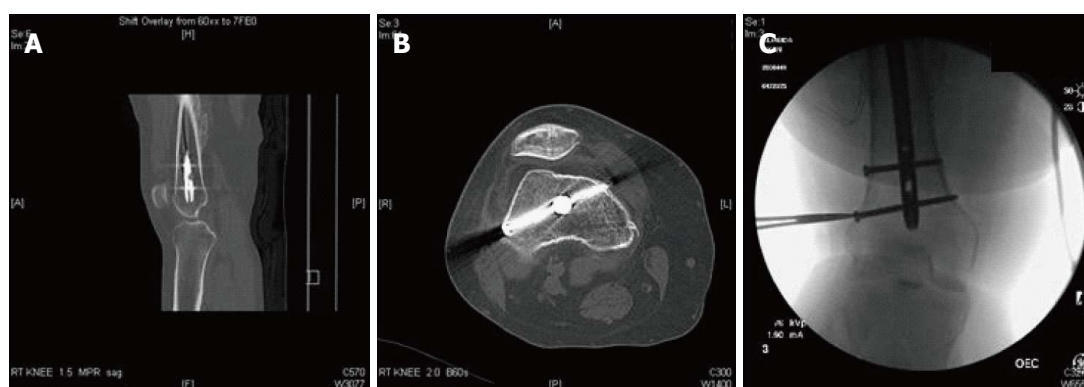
Preoperative imaging of femoral nail. A 380 mm × 11 mm Synthes trochanteric femoral nail was in place from prior and now well-healed femoral neck fracture. Two 5 mm diameter distal locking screws were used. The distal-most locking screw was placed in the distal femur approximately 20 mm superior to the trochlear notch and oriented from posterolateral to anteromedial, in close proximity to the posterolateral femoral cortex and planned femoral tunnel. A: Sagittal; B: Axial CT images; C: Intraoperative fluoroscopic radiograph. CT: Computed tomography.
